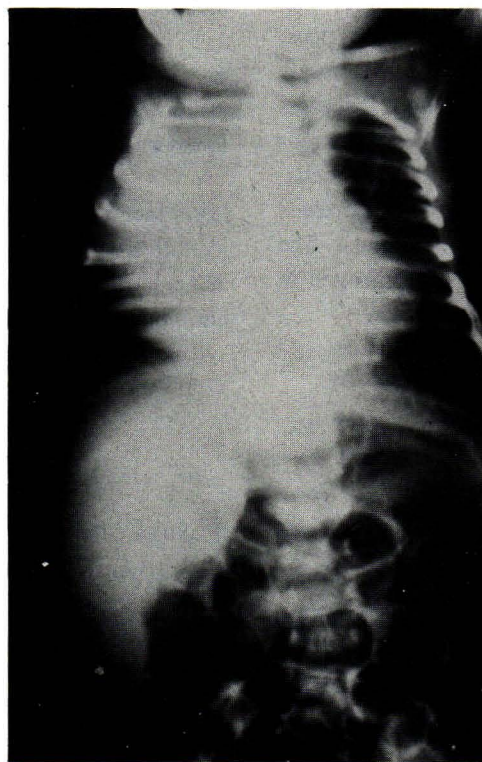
Figure Chest X-ray showed a large non-calcified right anterior mediastinal mass.
